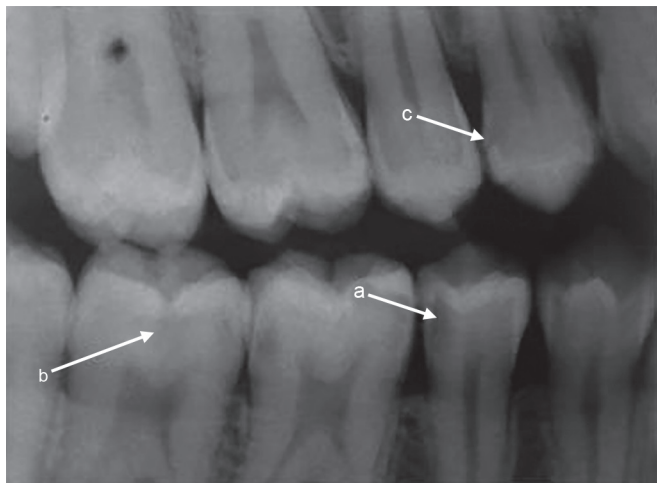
Bite-wing radiograph shows different stages and sites of carious lesions: Arrow a showing approximal cavitated caries; Arrow b showing occlusal cavitated caries; and Arrow c showing approximal enamel caries
